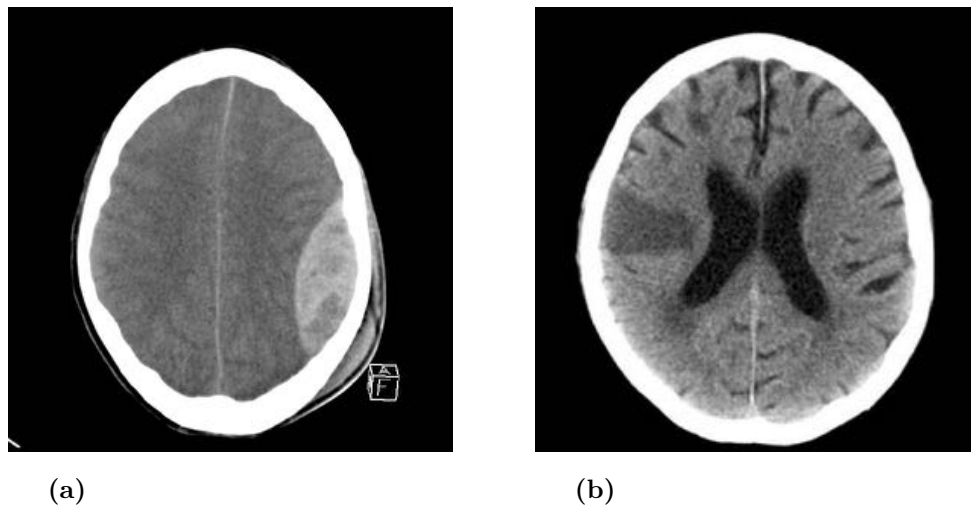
Brain CT image findings. Image (a) is the typical hyperdense presentation of a haematoma on CT. Image (b) is a case of ischaemic infarction presented as a hypodense region.
